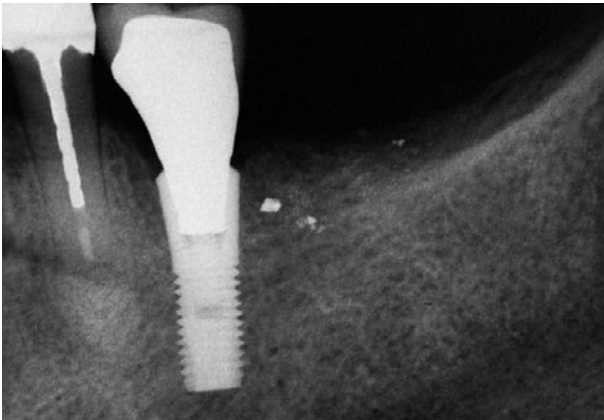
Postoperative radiograph showing implant and crown. (Implant placement by Kenneth H. Peskin, DDS, Skokie, IL.)
